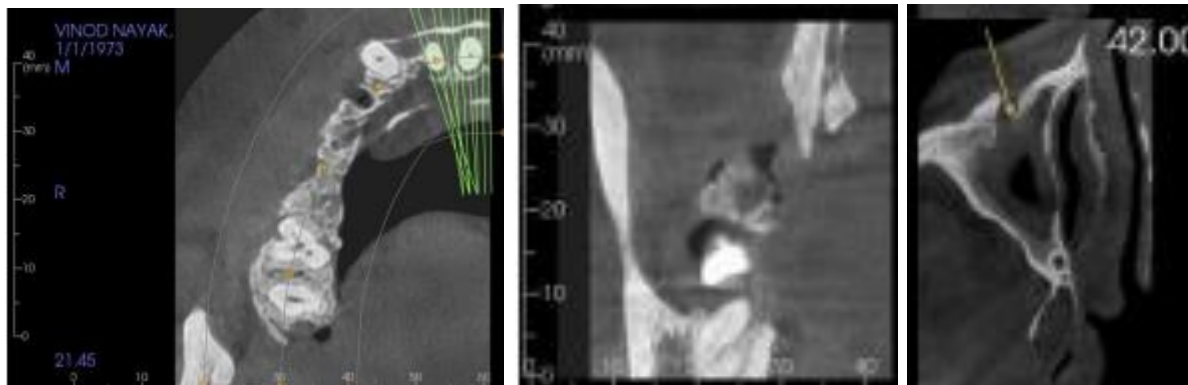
Axial section in CBCT
